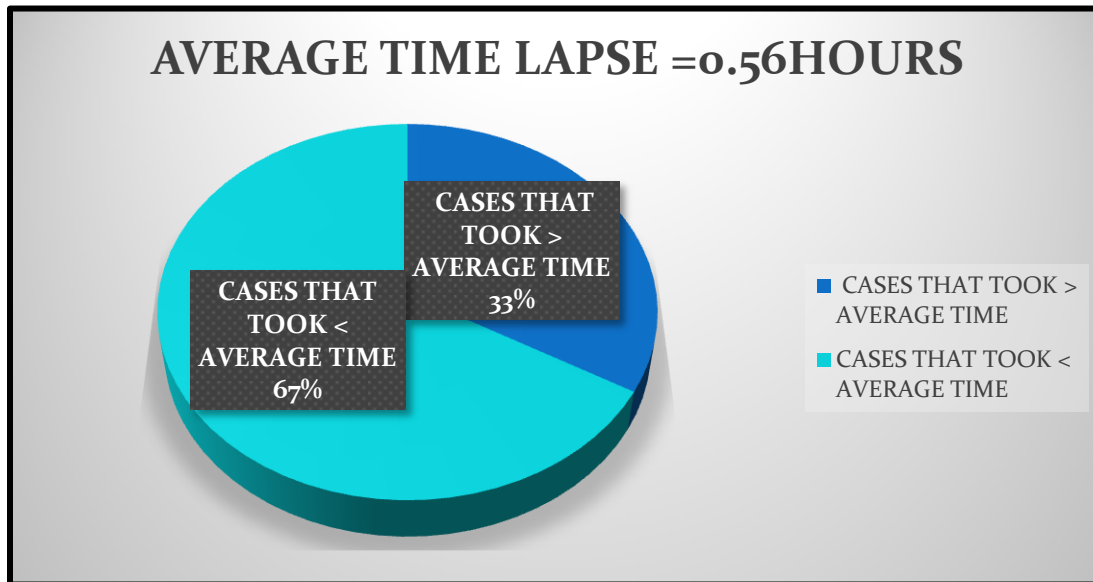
TIME LAPSE BETWEEN ORDER TIME & THE TIME AT WHICH X-RAY WAS TAKEN
